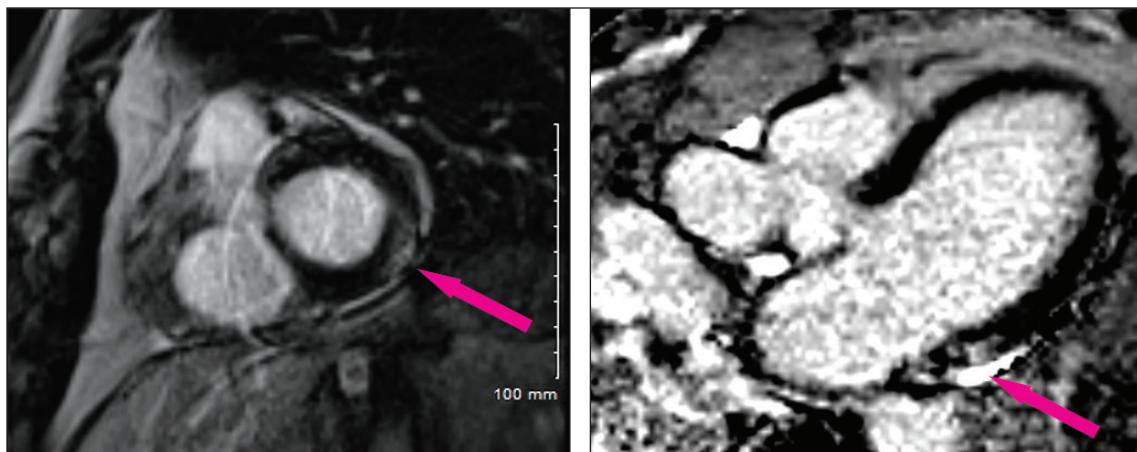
Cardiac MRI images demonstrating a subepicardial inferolateral delayed enhancement pattern in short-axis imaging (left) and three-chamber long-axis imaging (right).
